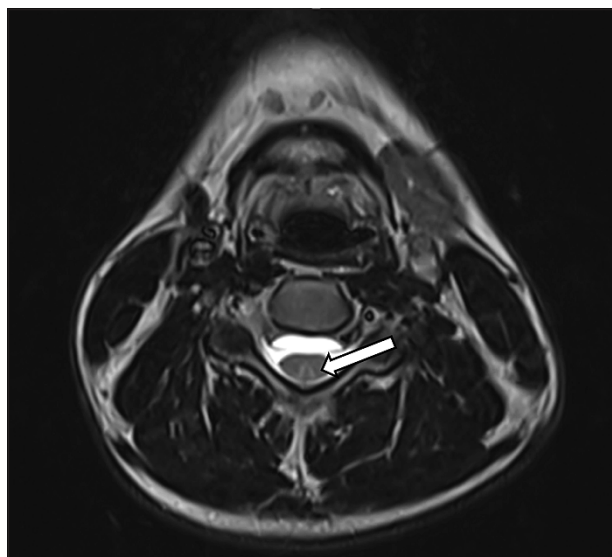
Axial T2-weighted MRI image of the cervical spinal cord demonstrating T2 hyperintensity in the dorsal spinal cord extending from C2 to C6
